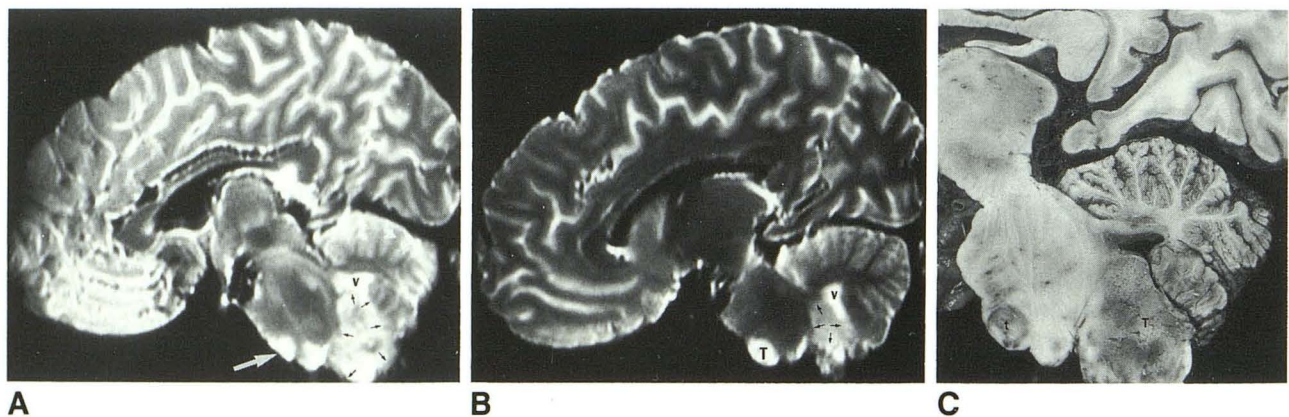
A, Midsagittal postmortem T2-weighted image in a 13-year-old boy who presented 2 years previously with diplopia and headache and was treated with radiation therapy at an outside institution. There is a discrete focus (*large arrow*) of high signal intensity in the lower pons. The lower pontine area of signal abnormality is believed to represent an artifact of fixation as no discrete tumor focus was found at that level. The right cerebellar tonsil (*small arrows*) is markedly enlarged and is also of high signal intensity. The fourth ventricle (V) is displaced rostrally by the mass. (Premortem MR not performed.)
